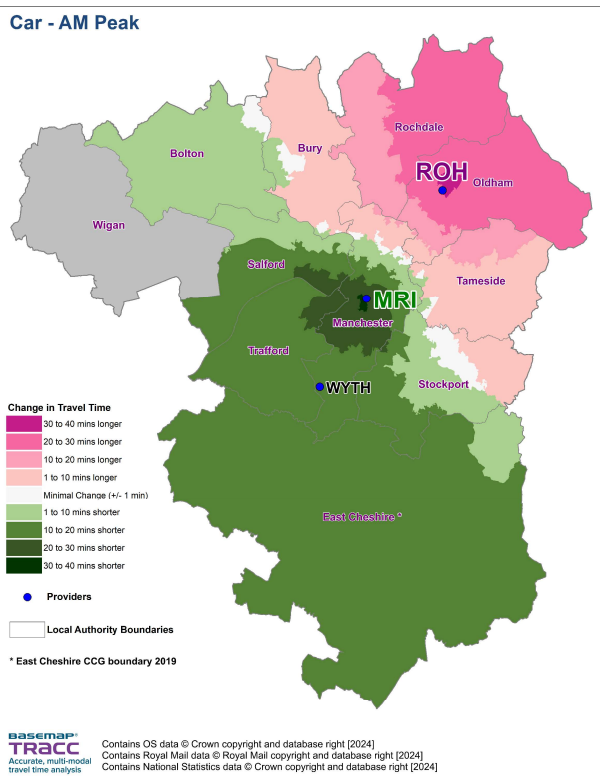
Change in Car AM Peak Travel Times, ROH to MRI, and Total Car AM Peak Travel Time to MRI
